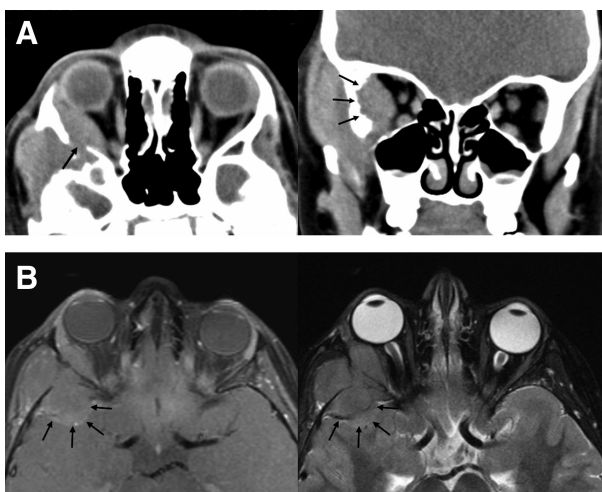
A, Axial and coronal CT. The lesion involves the right lateral orbit and temporalis fossa with intracranial extension (arrows). B, T₁-weighted, post contrast (left) and T₂-weighted (right) axial MR images with a homogenous signal and intracranial extension (arrows). Note the poor enhancement of the mass with gadolinium.
